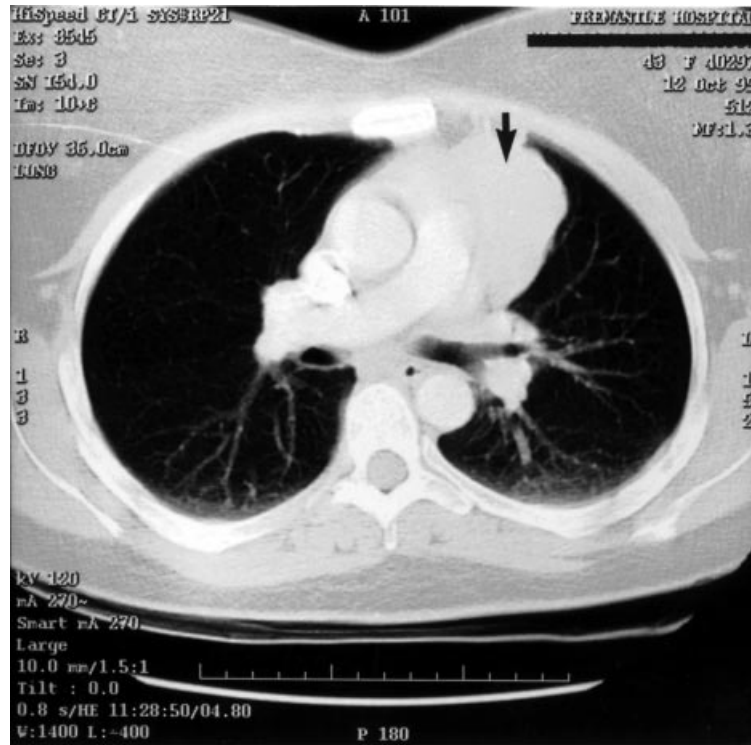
CT scan with i.v. contrast shows large thymoma (arrowed) anterior to the ascending arch of the aorta and right pulmonary artery.
